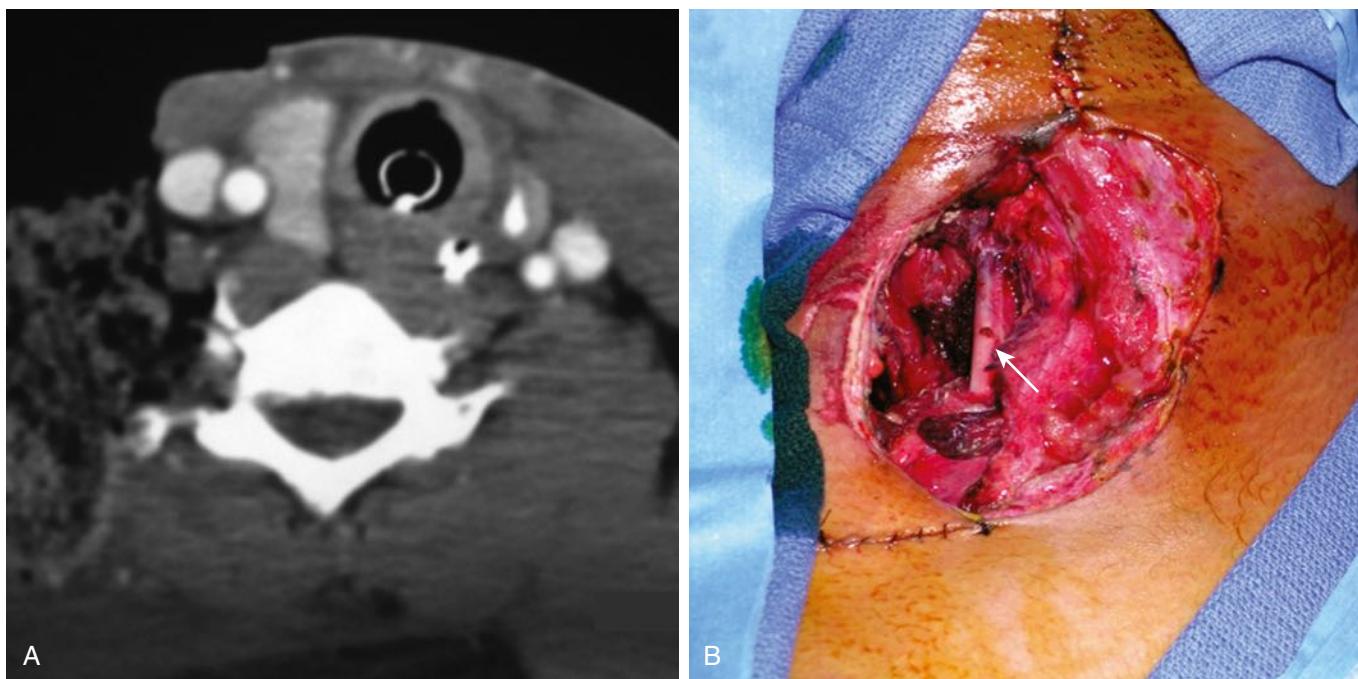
This patient sustained a high-velocity gunshot wound to zone I of the neck. On initial evaluation, he did not have hard signs of a vascular injury. (A) CTA demonstrates no injury to the internal jugular vein or common carotid artery. In addition, there is no injury to the aerodigestive tract. (B) The patient's wound was debrided in the operative suite; the arrow marks the cords of the brachial plexus.
